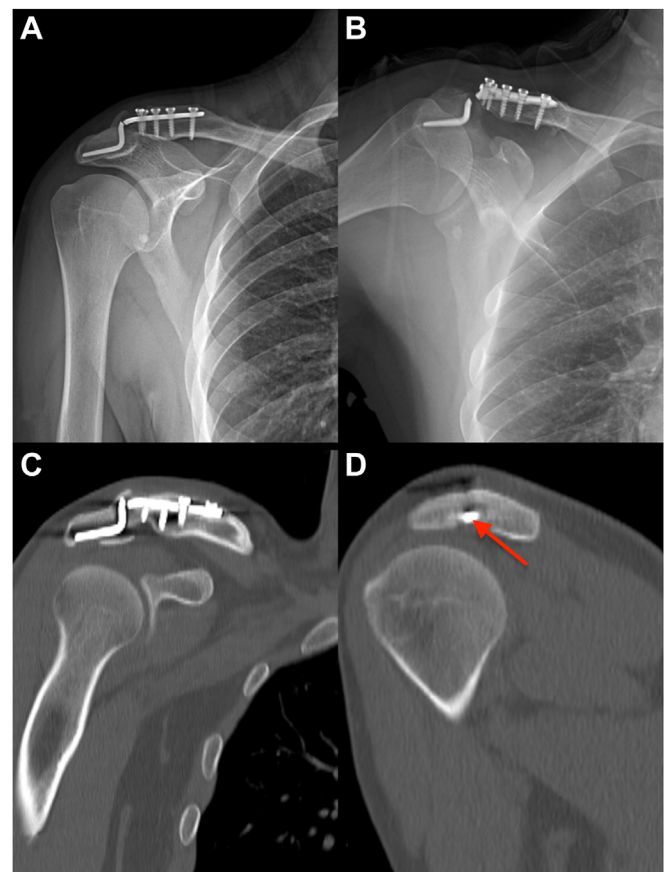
Broken HP is seen in the shoulder (A) AP and (B) Zanca view radiographs of the patient, who applied to our clinic due to shoulder pain. In the patient's shoulder CT (C) coronal and (D) sagittal sections, the distal hook fragment is shown with a — and has migrated superiorly within the acromion. HP, hook plate; CT, computed tomography; AP, anteroposterior.
